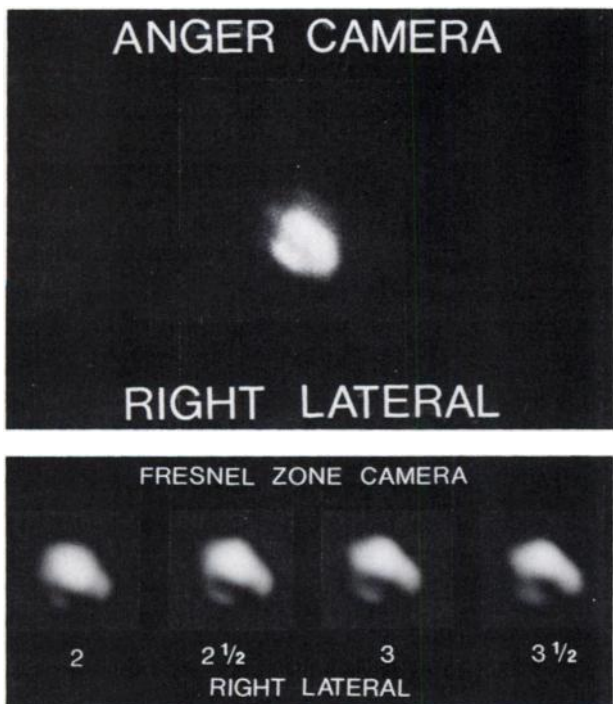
Myocardial perfusion scintigraphy with Anger camera (top), and Fresnel zone-plate camera (bottom), after occlusion of left circumflex artery (right lateral view). Perfusion defect along inferior wall is more clearly defined on Fresnel-zone image.
